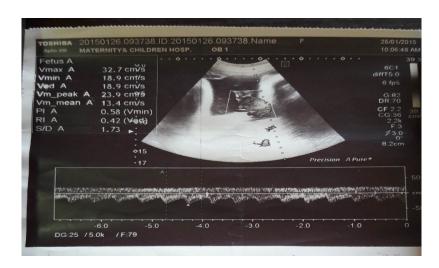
shows normalColor Doppler of the umbilical artery waveform at 33Wks.
